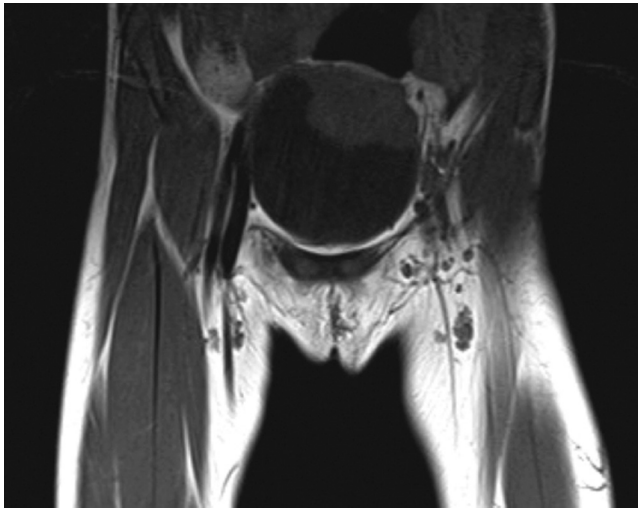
A T1-weighted coronal magnetic resonance image shows a lobullary, isointense mass in the vesical dome.
